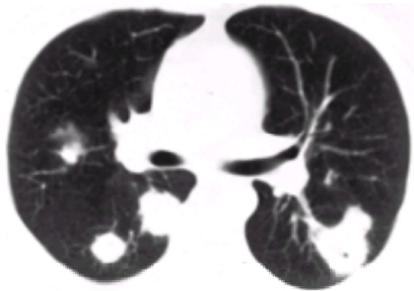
Wegener's granulomatosis. CT demonstrates multiple focal nodules in a 40-year-old man. Open lung biopsy demonstrated a necrotizing granulomatous vasculitis consistent with Wegener's granulomatosis. (Reproduced with permission from Orens JB, Sitrin RC, Lynch JP III. The approach to nonresolving pneumonia. *Med Clin North Am* 1994; 78;1160, Fig. 8B.)
